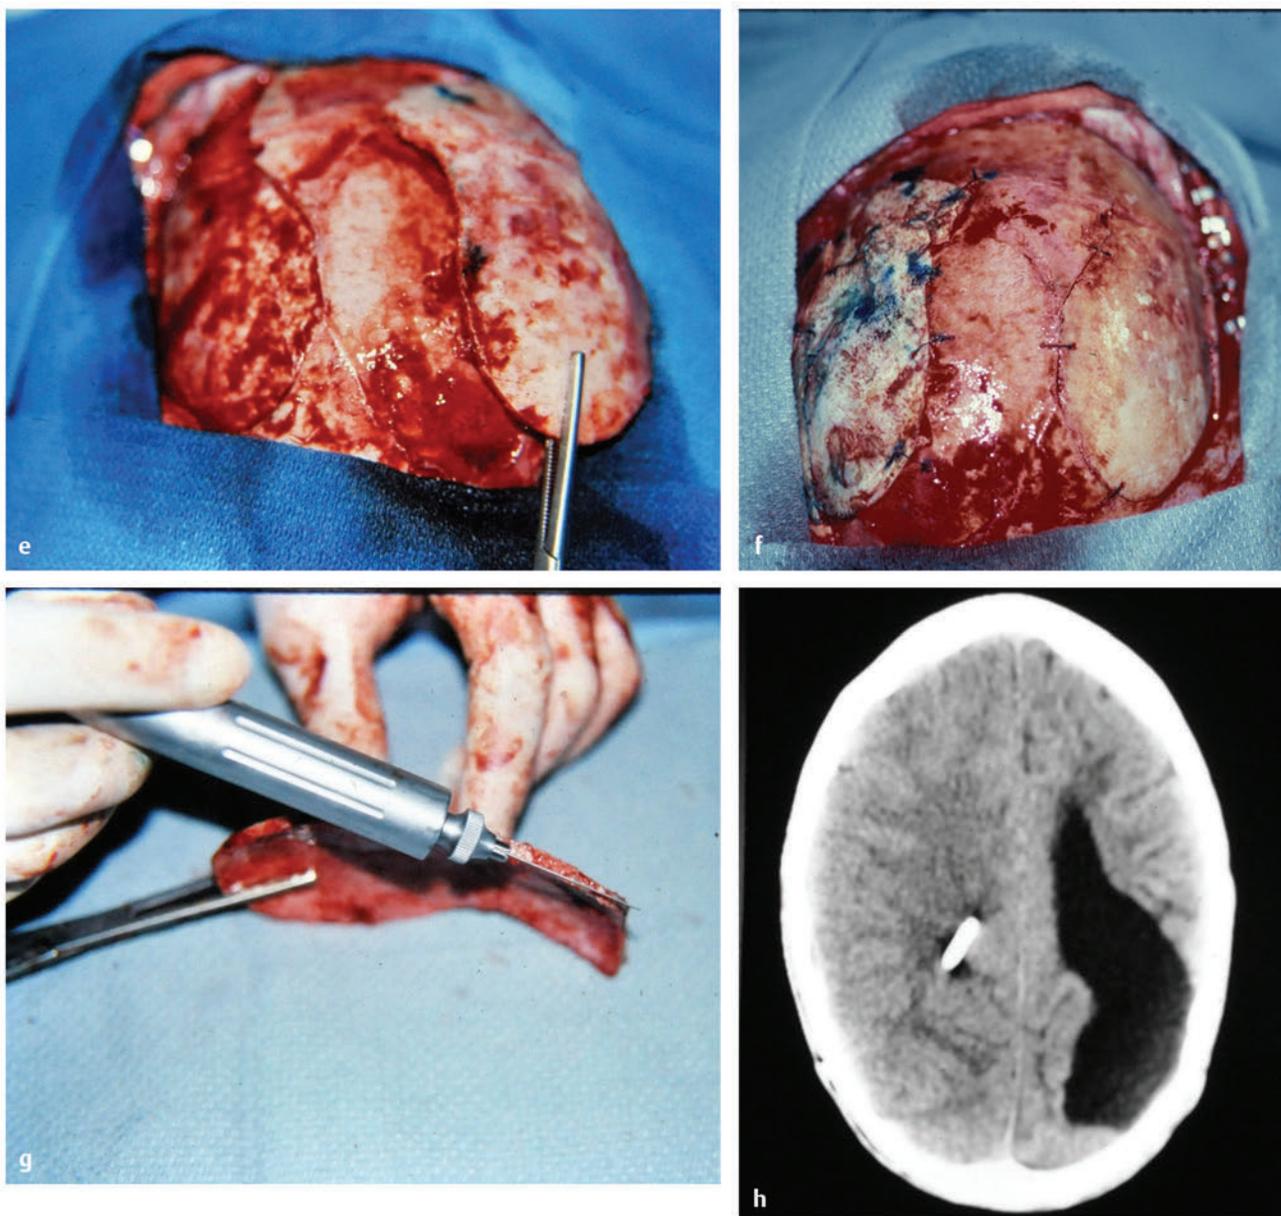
(continued) (e) The full-thickness bone flap from the donor site (right parietotemporal region) is being elevated here and held by the Kelly clamp. (f) Both units of bone have been placed into position and anchored. The inner table has gone to the donor site on the right and the outer table to the defect site on the left. (g) A technique to split a full-thickness bone graft by using an oscillating saw and following the bone marrow space in the bone, just between the inner and outer tables of the skull bone. (h) CT of the patient done 8 years after the calvarial reconstruction with the split grafts shows the grafts now well incorporated. Additionally, no problems developed with displacement or infection in either bone graft. This patient has now been followed for more than 20 years, and there have been no further issues with the grafts.
